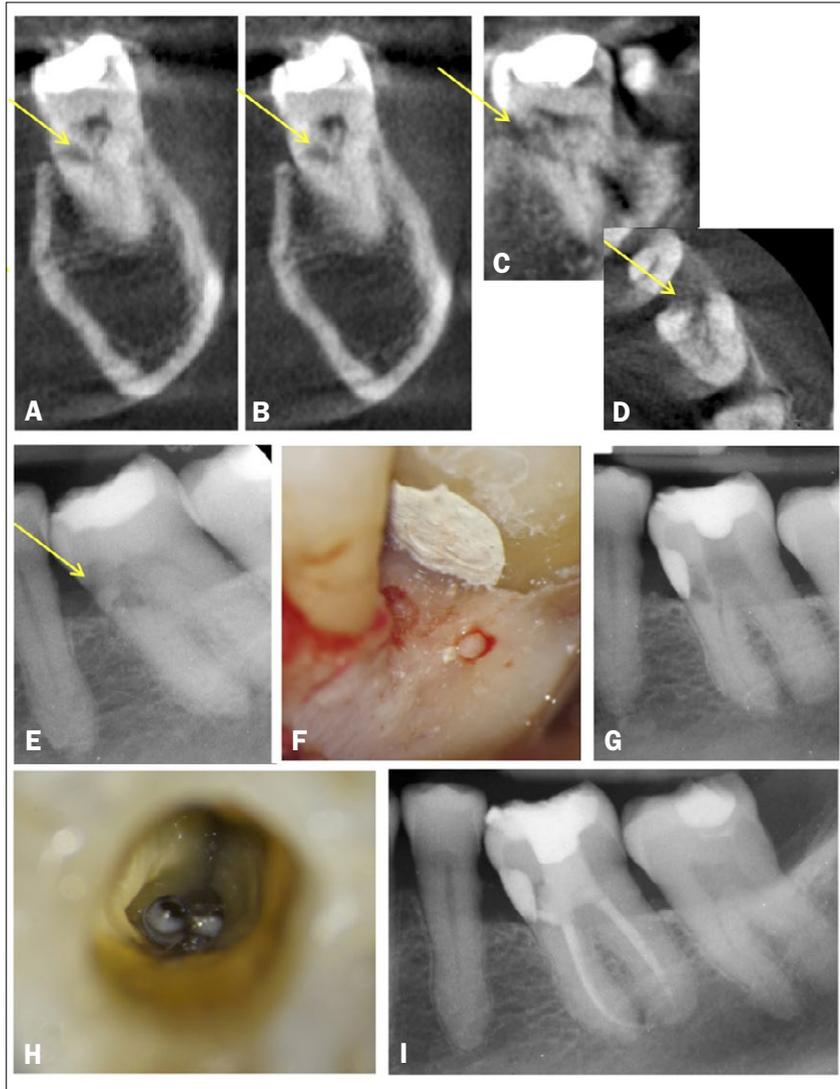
(video 7). ECR case 7. A, B) Frontal, C) sagittal and D) axial CBCT slices let diagnose an ECR of 3.7 (yellow arrows). E) Two-dimensional X-ray radiograph of 3.7 showed the resorption (yellow arrow) on the mesial aspect of the tooth. F) External defect restoration using SuperEBA® Cement. G) Two-dimensional X-ray of external defect restoration. H) Internal defect restoration using MTA. I) Postoperative radiographic control.
